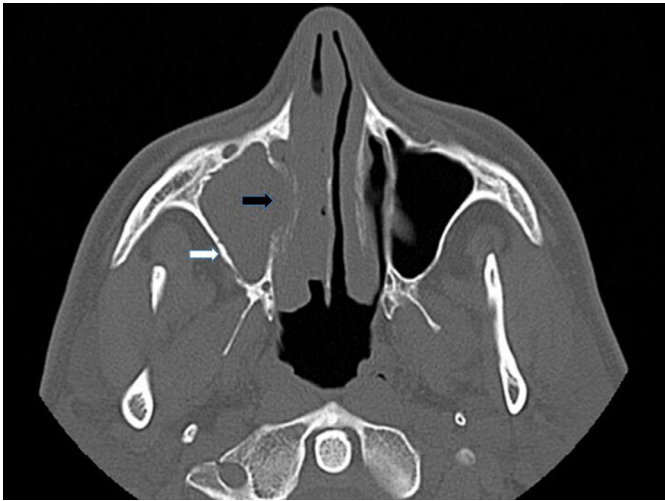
Axial computed tomography section
